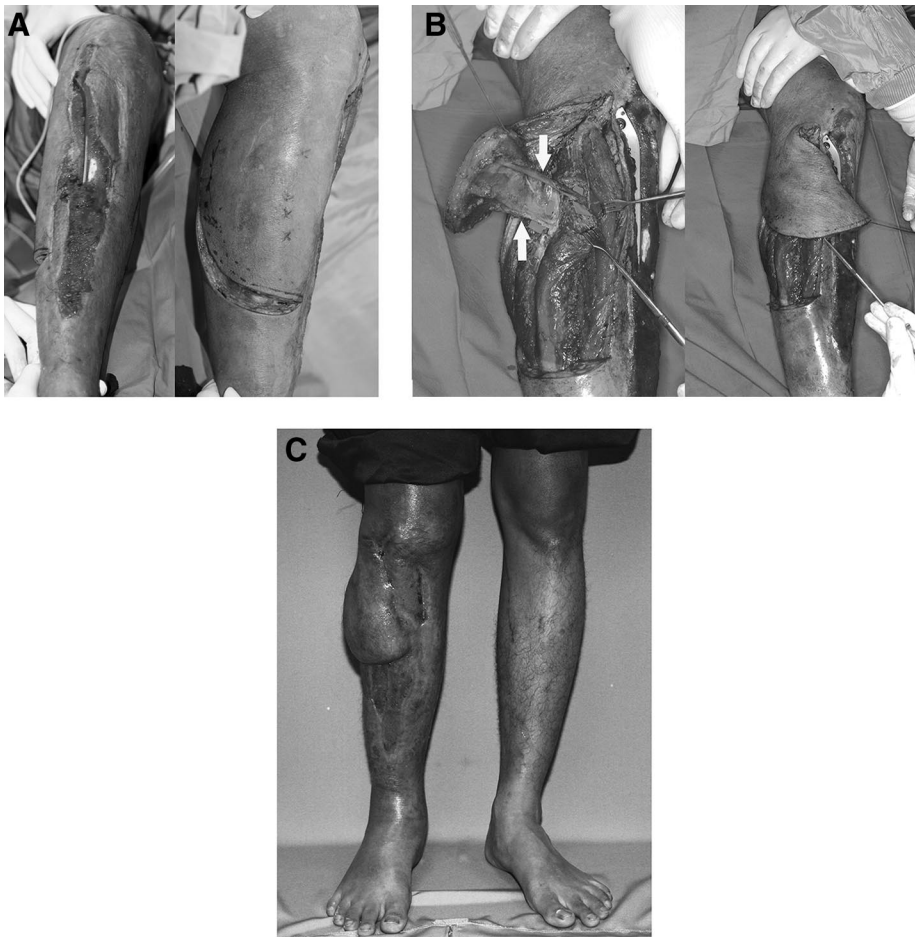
Patient of Case 3. A: Left, Right-leg traumatic wound after 2 months of V.A.C. therapy. The patient has a 14- × 4-cm area in the upper and middle thirds of the leg, with an exposed plate and bone. Right, Coverage with a perforator-sparing transposition flap was performed. B, Left, Intraoperatively 2 perforators supplying the tip of the flap were preserved and dissected to their respective origin. One was a musculocutaneous perforator from the anterior tibial artery (top arrow) and the other was a septocutaneous from the peroneal artery (bottom arrow). Right, Complete coverage of the plate with the flap. C, The patient at 4 months' follow-up, showing complete survival of the flap. The patency of the 2 perforators was confirmed by handheld Doppler.
